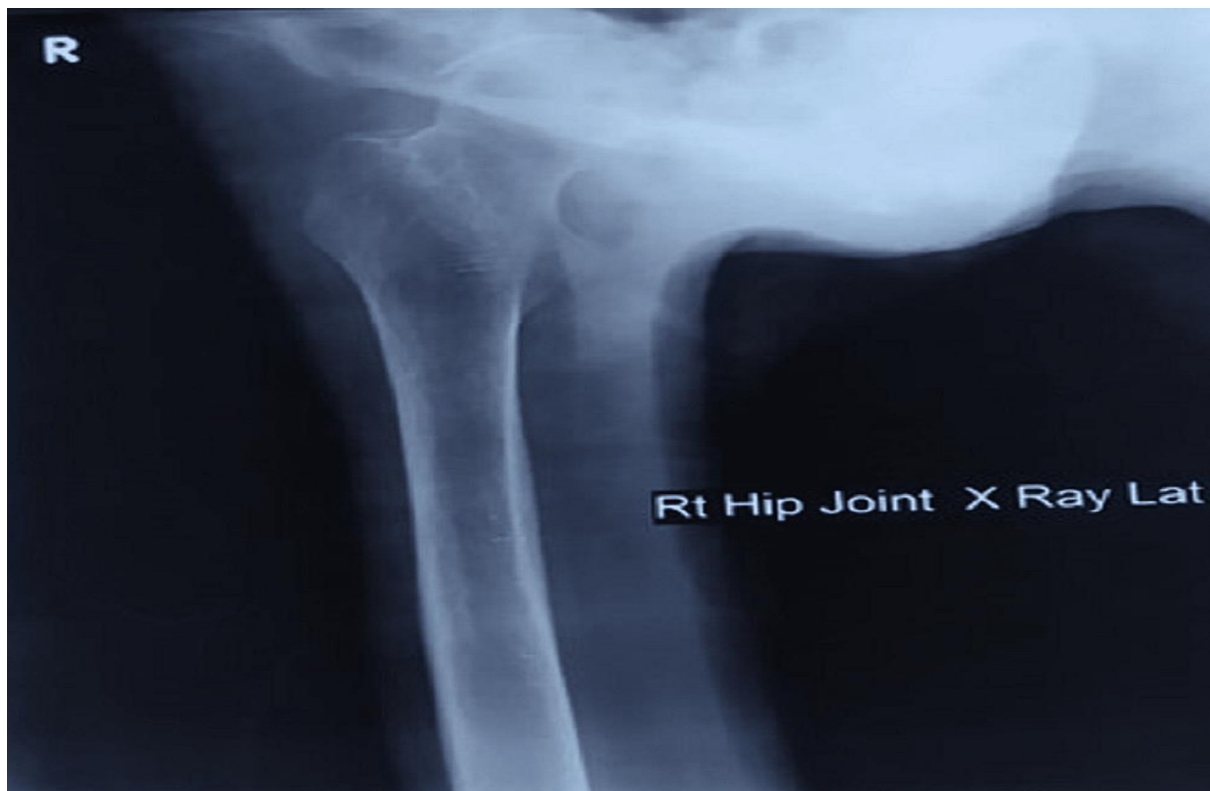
X-Ray of right hip joint
